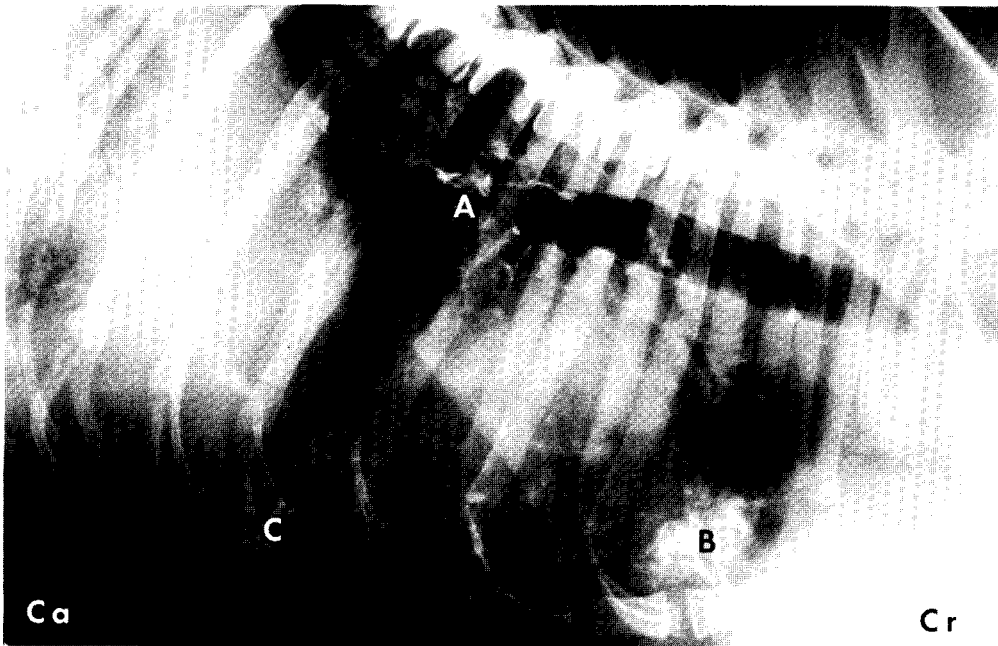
Lateral X-ray of the thorax obtained 3 days after the injection of  $\text{CaWO}_4$  into the pleural space. The appearance of the tungsten marker is highly distinctive and has accumulated in areas corresponding to the paravertebral costal sinus (A), parasternal lymph nodes (B) and retrocardiac mediastinal pleural folds (C). Ca=caudal; Cr=cranial.
